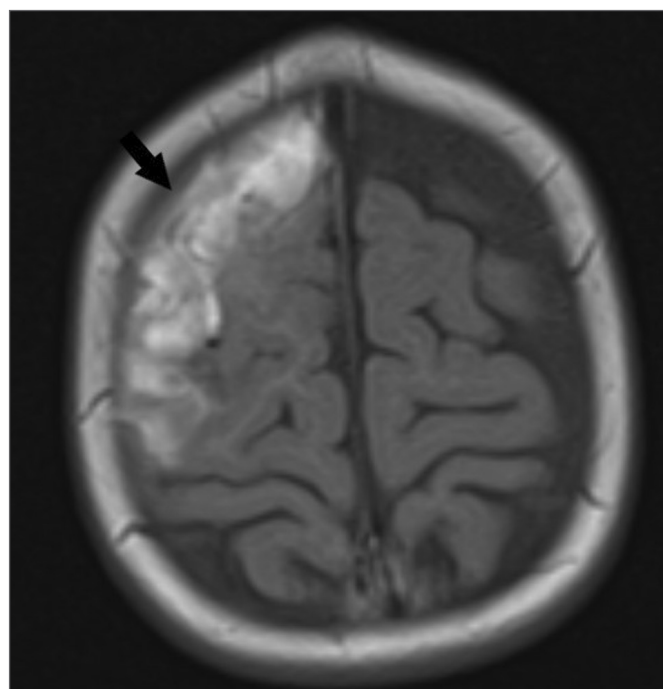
Axial T1 weighted MRI. Extra axial effusion compatible with subacute subdural hematoma is shown (arrow). The right frontal cortex is slightly compressed by hematoma.
